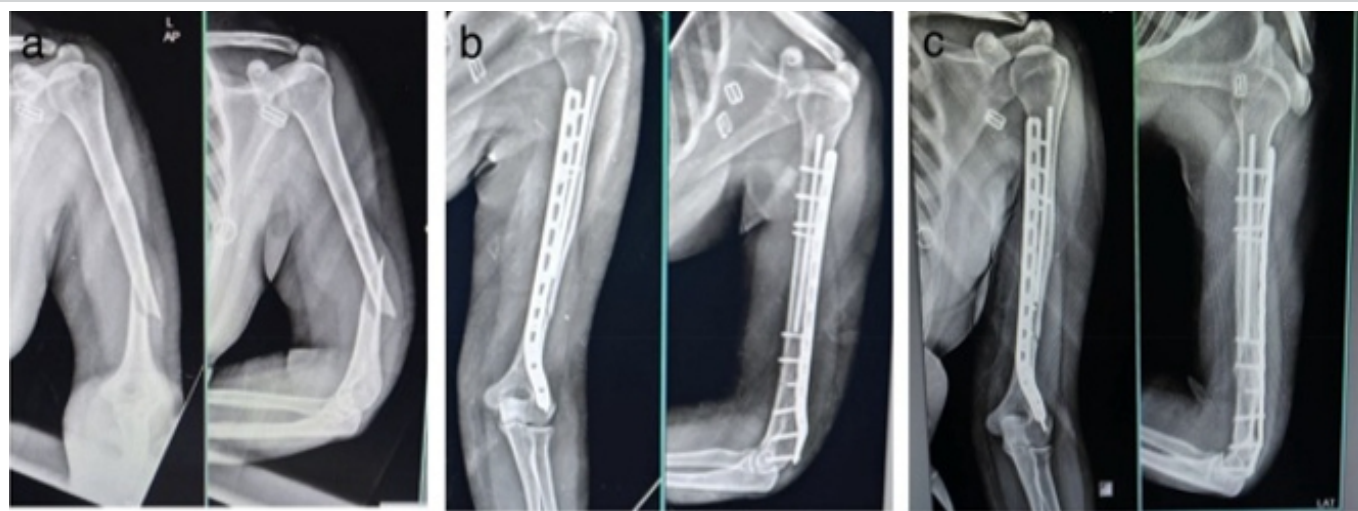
(a) pre-operative X-rays; (b) post-operative X-rays; (c) 2 month follow-up X-rays.
